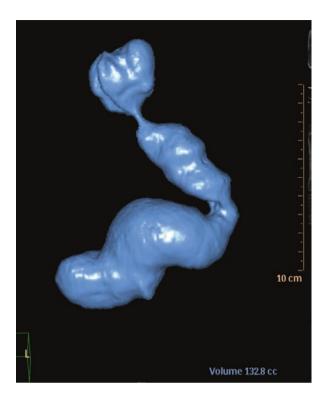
Sleeve migration in the virtual CT scan
